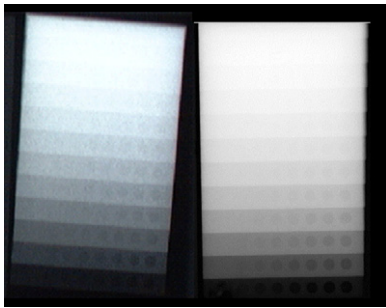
Radiographs obtained with Ekataspeed Plus film (left) and with Dixel digital intraoral radiographic system (right). Note the difference of radiographic contrast and noise.
